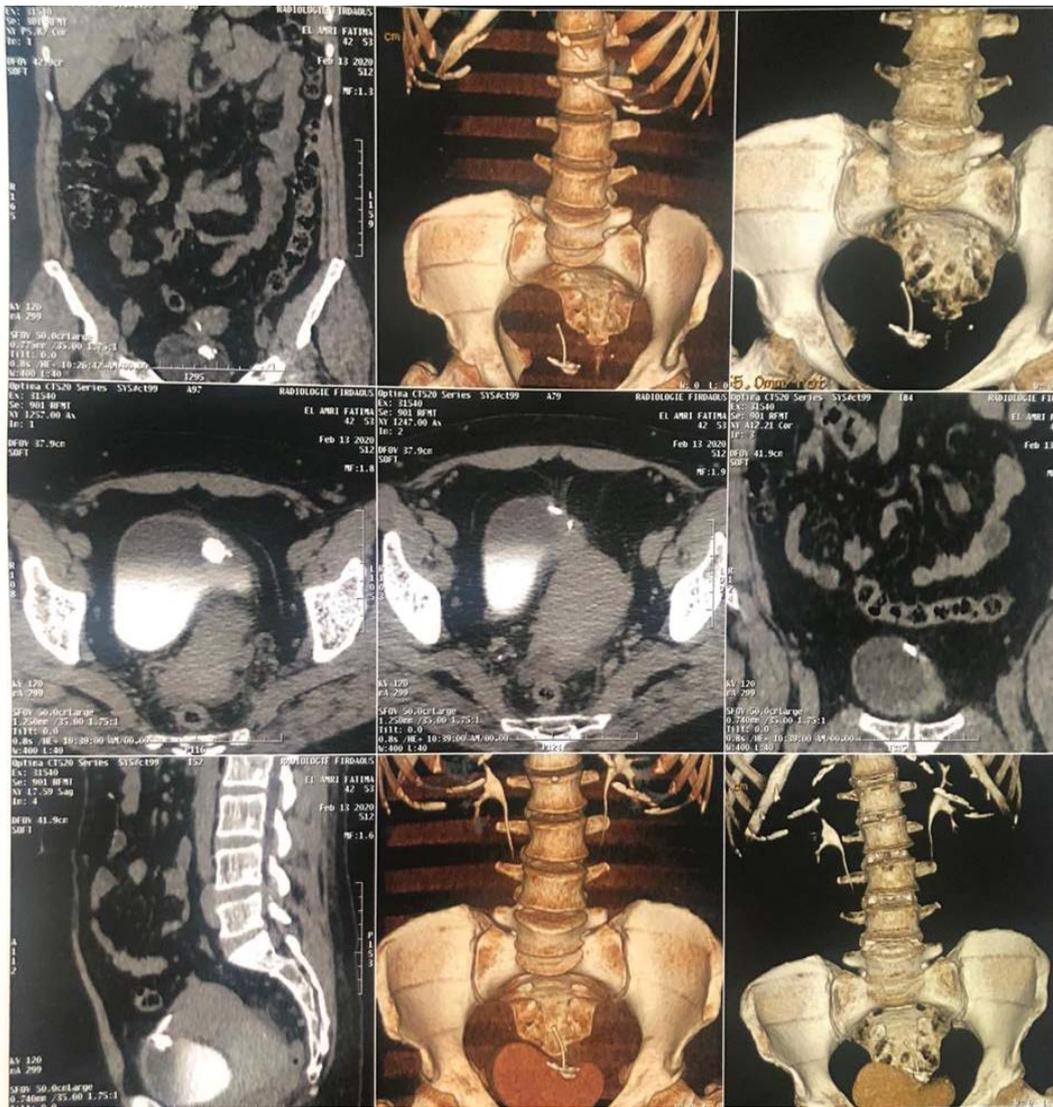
Pelvic CT scan showing the bridge between the uterus and the bladder.
